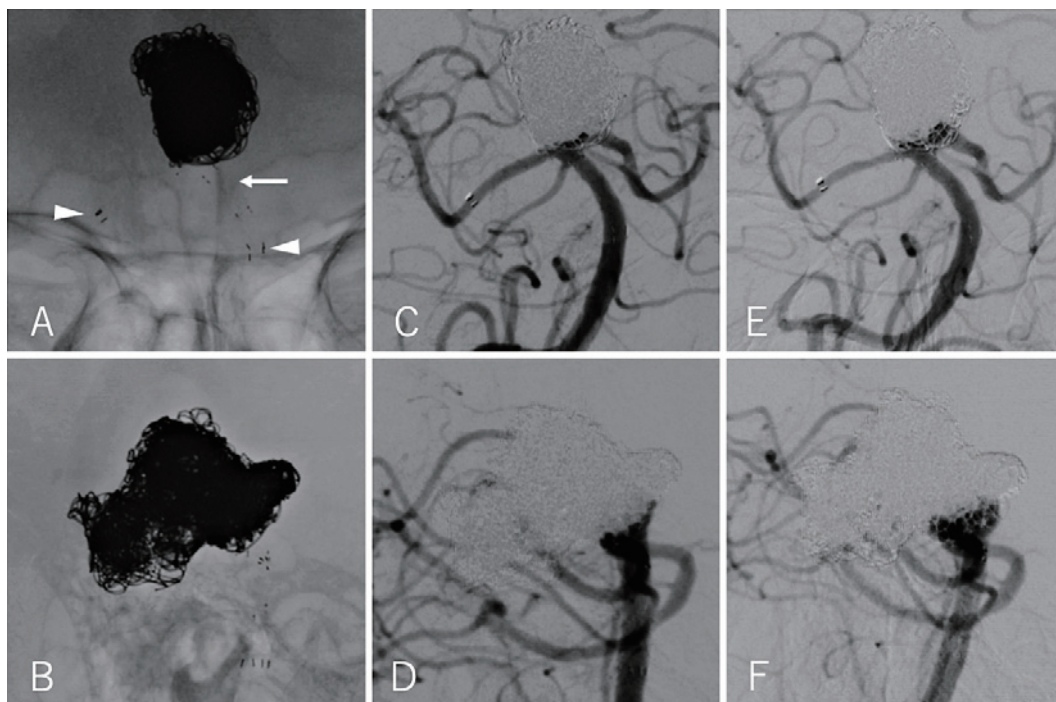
Postoperative findings after stent-assisted coil embolization. The anterior view (A) and lateral view (B) of the X-ray photograph show an additional stent (arrowhead) and a previously deployed T-shaped PulseRider (white arrow). Anterior view (C) and lateral view (D) of digital subtraction angiography (DSA) showing appropriate aneurysm obliteration after additional stent-assisted coil embolization. Anterior view (E) and lateral view (F) of DSA taken 6 months later showing no recanalization.
